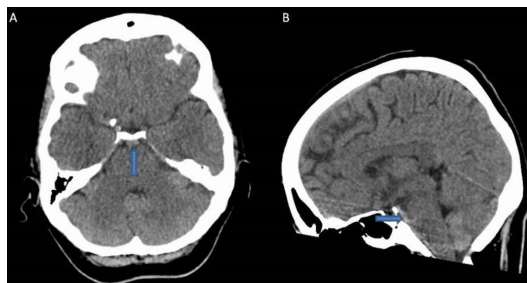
(A) Axial view of CT brain showing perimesencephalic subarachnoid haemorrhage (arrow). (B) Sagittal view of CT brain showing perimesencephalic subarachnoid haemorrhage (arrow).
